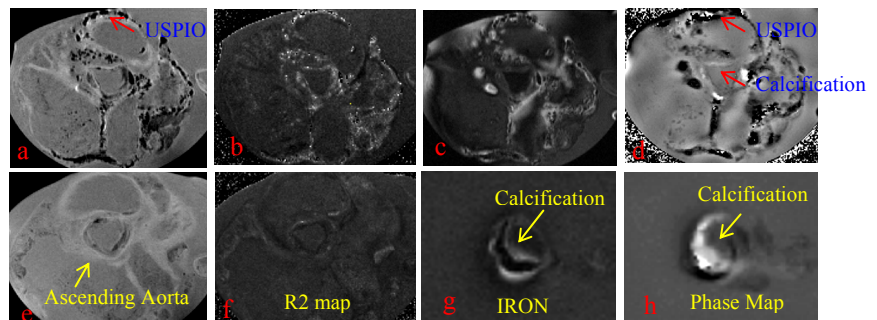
MRI of USPIO uptake in aortic plaque
